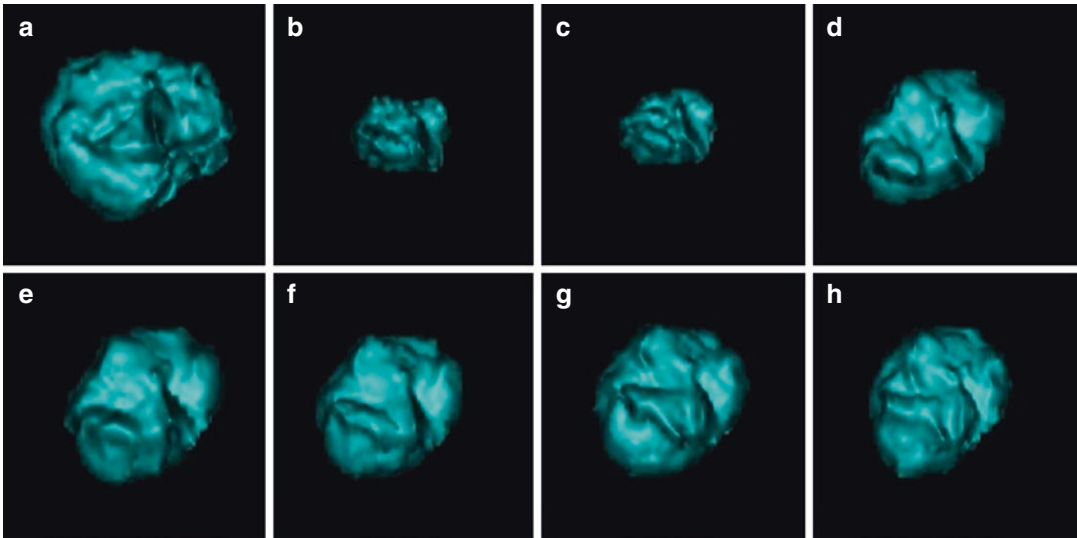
Computed tomography (CT) images of a segmented lung tumor from a woman aged 52 years who had stage IV lung adenocarcinoma with slow tumor growth. (Reprinted with permission from Cancer. 2013 Nov 1;119(21):3761–8). (a) The baseline CT scan revealed a dominant right upper lobe lesion measuring 14,495 mm³. (b) The patient received treatment with gefitinib, and her tumor volume significantly decreased, reaching the nadir, measuring 4121 mm³, at 8 months. (c–h) The tumor
